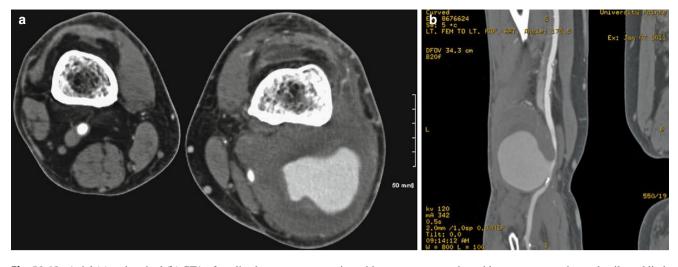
Axial (a) and sagittal (b) CTA of popliteal aneurysm presenting with venous compression with venous congestion and unilateral limb swelling. The aneurysm measured over 9 cm in greatest diameter
